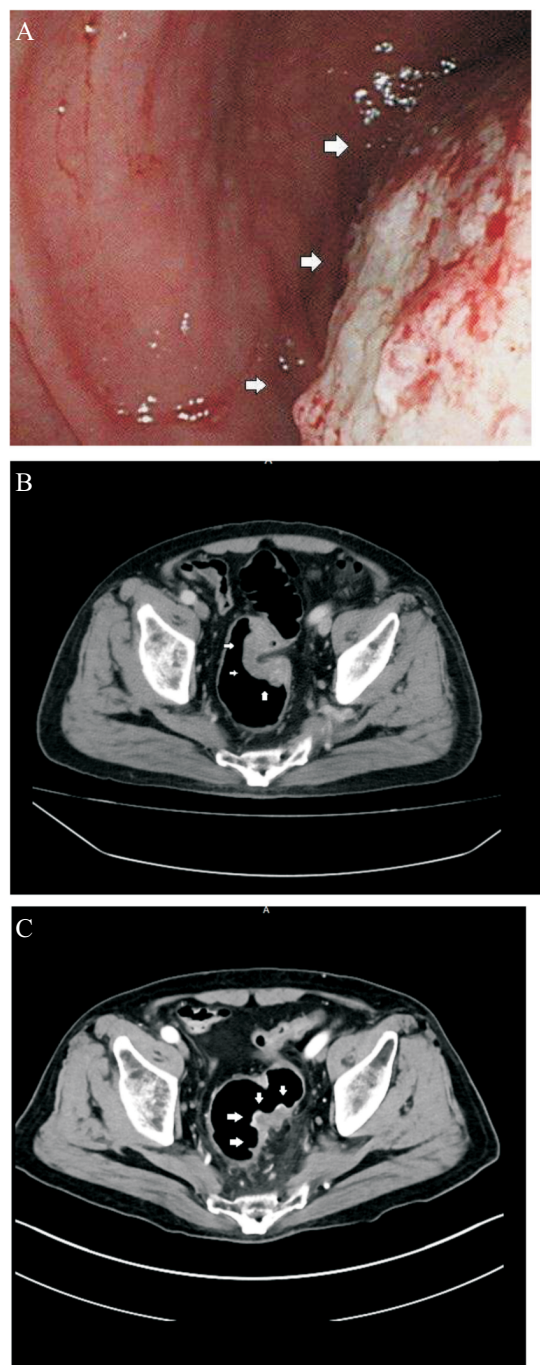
(A) An ulcerative tumor in the rectosigmoid junction with severe lumen stenosis. The arrow indicates the outline of the tumor. (B) The abdominal computed tomography (CT) scans showed that a rectosigmoid junction colon tumor with pericolic infiltration, the clinical stage was cT3N1M0, stage IIIB. (C) Follow-up abdominal CT after CCRT showing interval decrease tumor size and persistently some pericolic infiltration and interval shrinkage of regional lymph nodes (Partial response, PR according to RECIST criteria).
